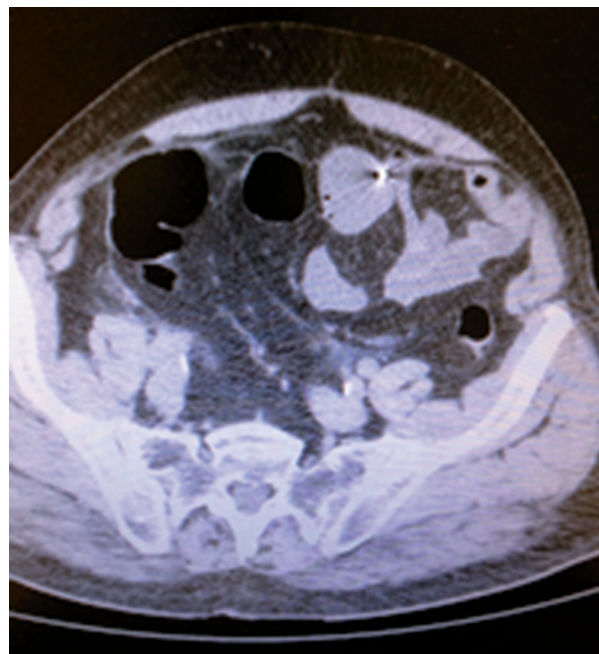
Abdominal CT scan showing another bullet into the bowel.
